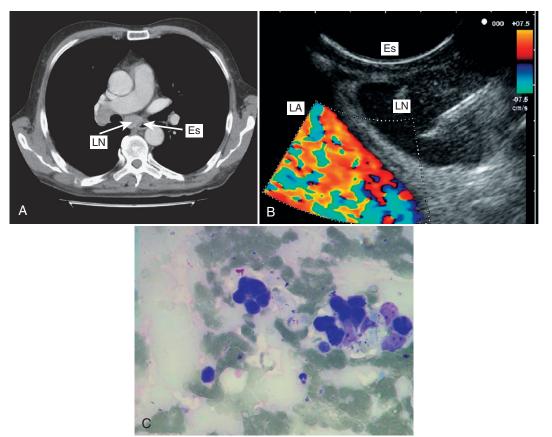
A 54-year-old man with proven non-small cell lung cancer who was fit for surgical resection. A, Computed tomography of the chest demonstrating a centrally located non-small cell lung carcinoma of the right lung and an enlarged subcarinal lymph node (LN). Es, esophagus. B, Real-time EUSguided aspiration of the subcarinal lymph node (LN) located between the esophagus (Es) and the left atrium (LA). C, Cytologic appearance of a lymph node metastasis.
